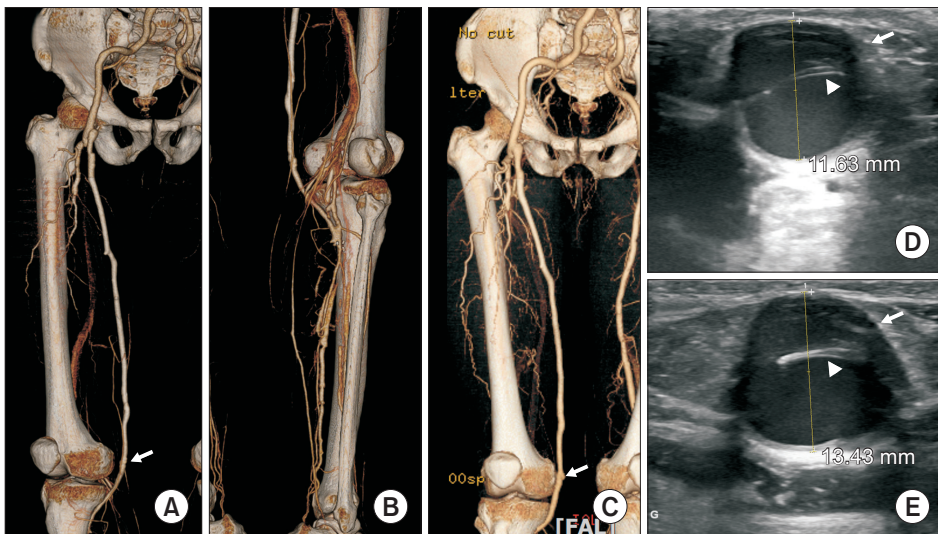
Serial follow-up images of computed tomography angiography (CTA) and duplex ultrasonography (DUS). One segment of the valve cusp in the great saphenous vein demonstrated progressive aneurysmal dilatation during follow-up (arrow) and a further hypertrophied valve cusp (arrowhead). (A) Postoperative CTA; (B) posterior view of postoperative CTA; (C) CTA 1 year after operation; (D) DUS 3 years after operation; and (E) DUS 6 years after the operation.
